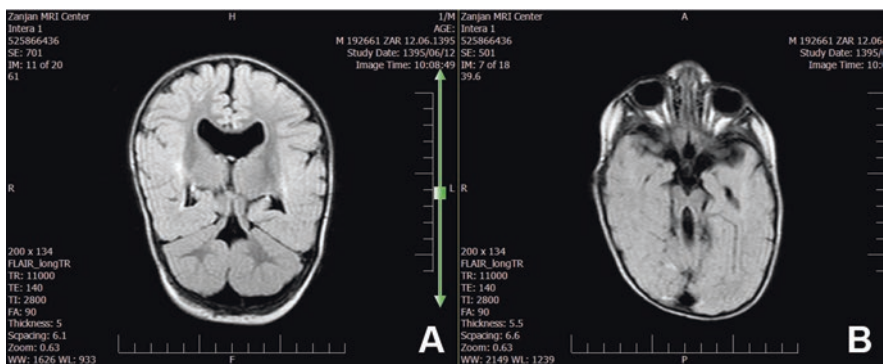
Joubert syndrome and related disorders. (a) Coronal T2 FLAIR brain image. The cerebellar vermis is aplastic and superior cerebellar peduncles are elongated. (b) Axial T2 FLAIR brain image. This image shows a deep interpeduncular fossa, elongated superior cerebellar peduncles with cerebellar vermis hypoplasia, which are characteristic of the molar tooth sign in Joubert syndrome
